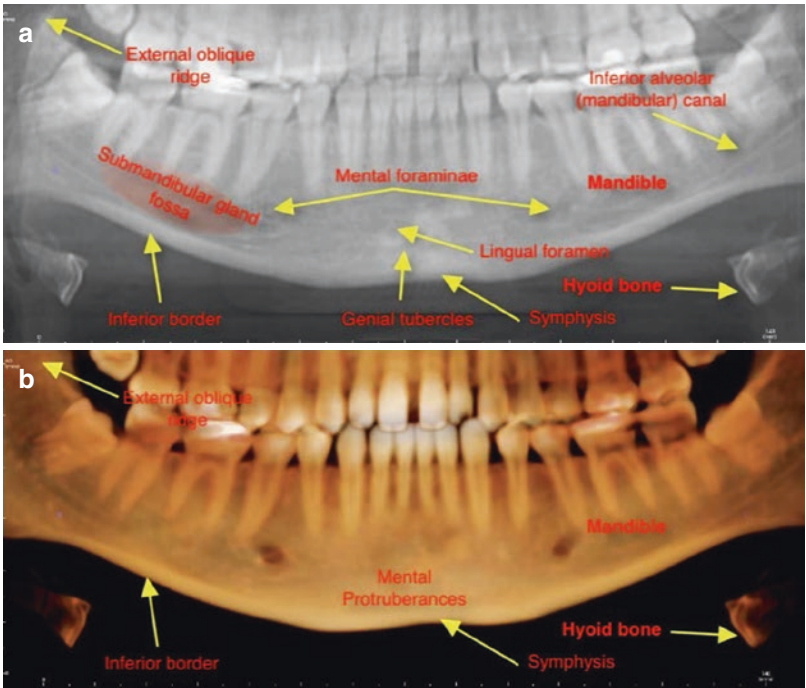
Specific topographic features and anatomic landmarks seen on CBCT reformatted panoramic ray sum (a) and volumetric rendered (b) images for Zone 4
